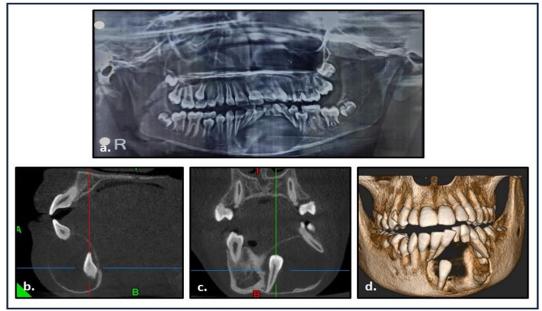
a. OPG showing well-defined unilocular corticated radiolucency in the anterior mandible with associated impacted left lateral incisor and its root reaching up to the inferior border of the mandible. b and c. CBCT showing sagittal view and coronal view. d. 3D view showing the tumor and impacted tooth.
